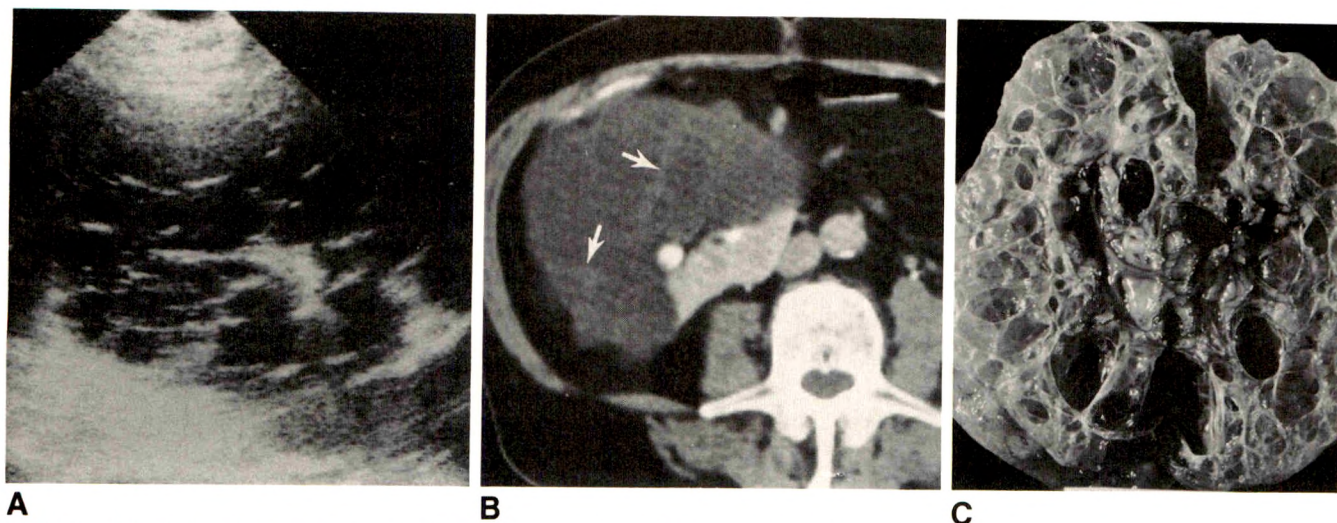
A, Sagittal renal sonogram shows multiple clustered cystic masses with echogenic septa replacing normal renal parenchyma.
